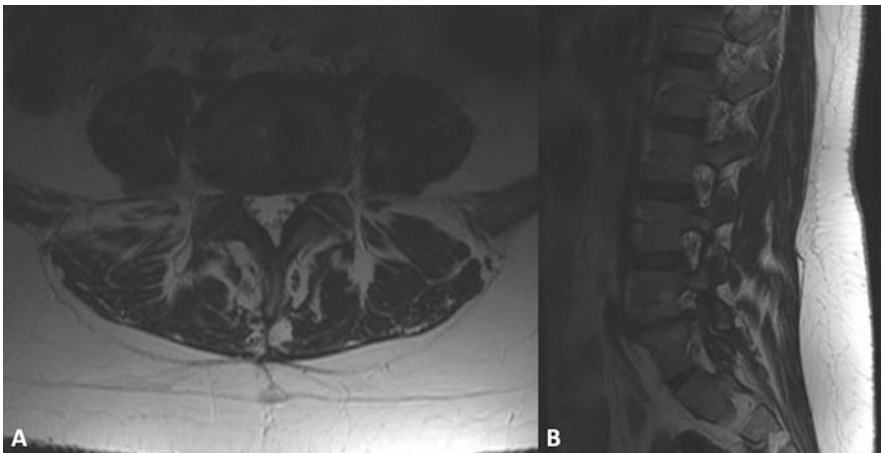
Preoperative (a) L4/5 axial and (b) right parasagittal T2-weighted MR images demonstrating marked degeneration of the residual L4/5 disc leading to mild compression of the right L4 and L5 roots
